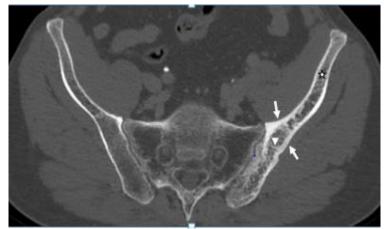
Axial CT scan of the pelvis shows cortical (large arrows) and trabecular (small arrows) thickening of the left iliac bone with maintained yellow marrow (star)
